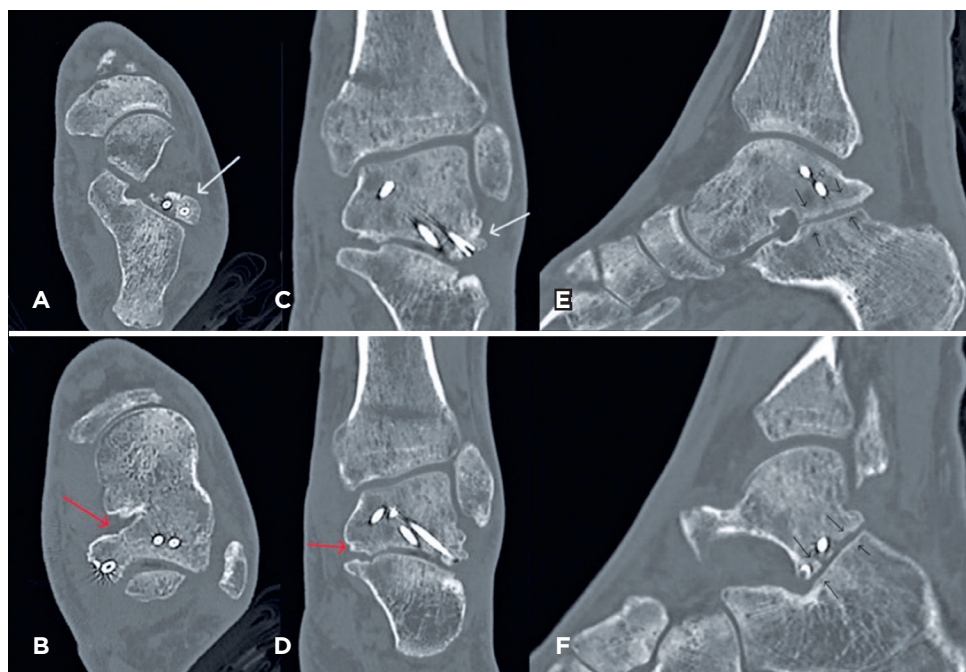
Computed tomography scan at week 24. (A and B) Axial view showing screws in the lateral process, non-articular (white arrow), and bone bridge (union) in the fracture of the posterior process (red arrow). (C and D) Coronal view showing bone bridge (union) in the fracture of the lateral process (white arrow), and in the medial tubercle (Cedell) of the posterior process (red arrow). (E and F) Sagittal views showing minimal changes due to subtalar osteoarthritis (short black arrows).
